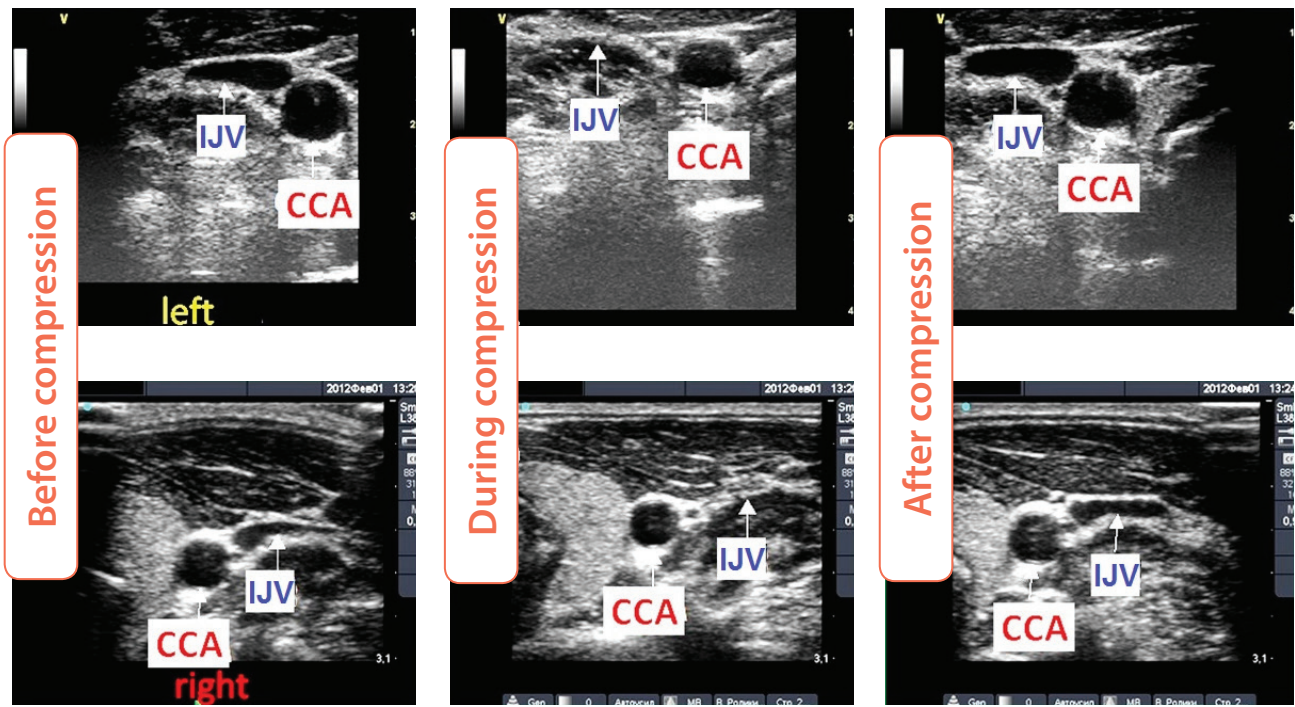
Ultrasound images in B-mode in axial plane before, during and after simultaneous compression of both internal jugular veins in a volunteer.
